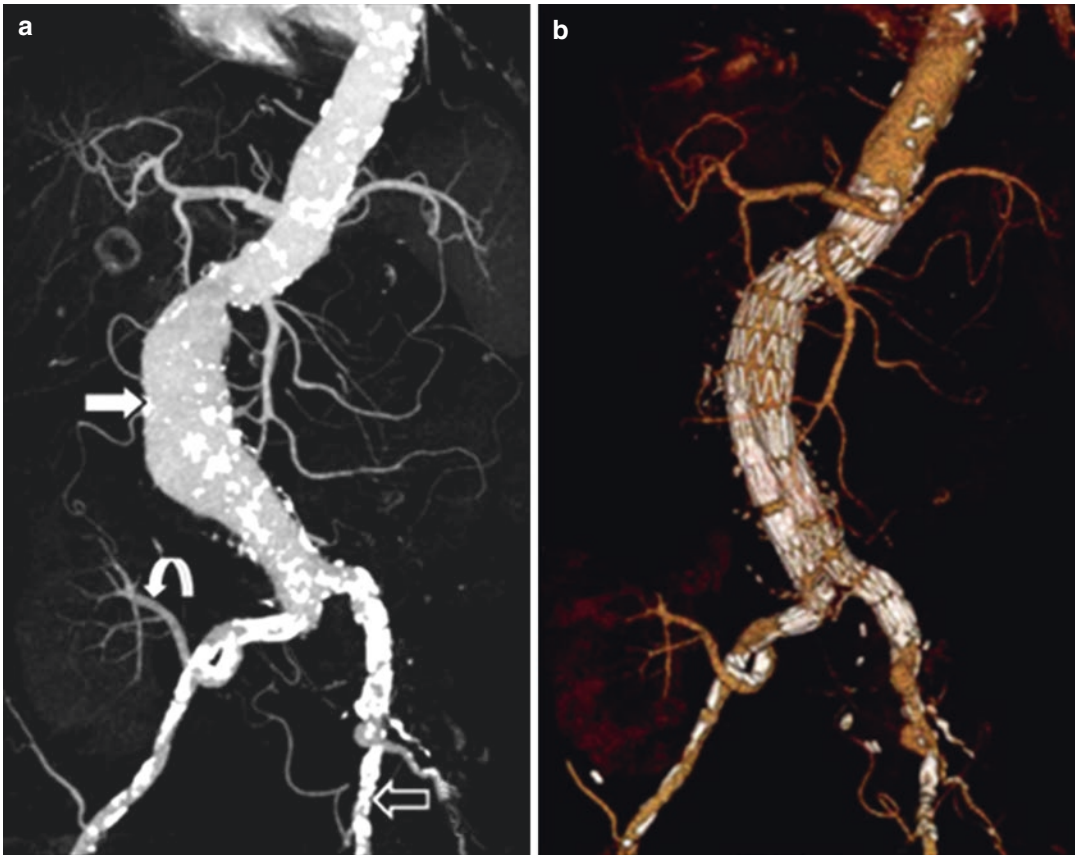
(a) CTA reconstruction showing an infrarenal aneurysm with the exact position of the renal, internal, and external iliac arteries with their measurements. (b) EVAR
